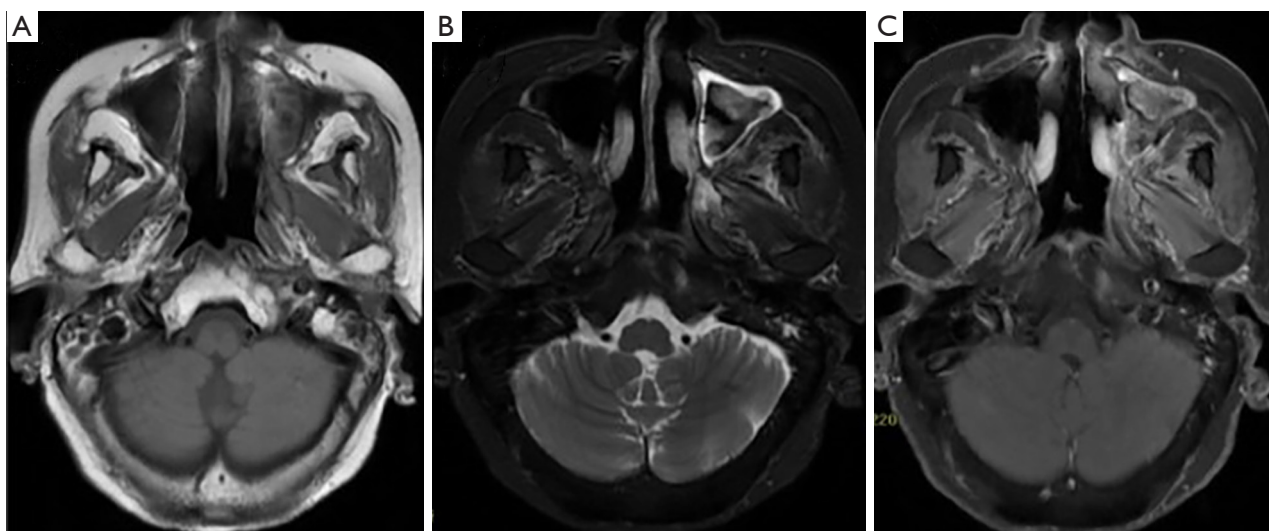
Head and neck MRI on 96th month after treatment. (A) T1W image, (B) T2W image, (C) T1W SPIR image. No significant evidence of abnormal enlargement or abnormal enhancing pattern except left maxillary sinusitis.
